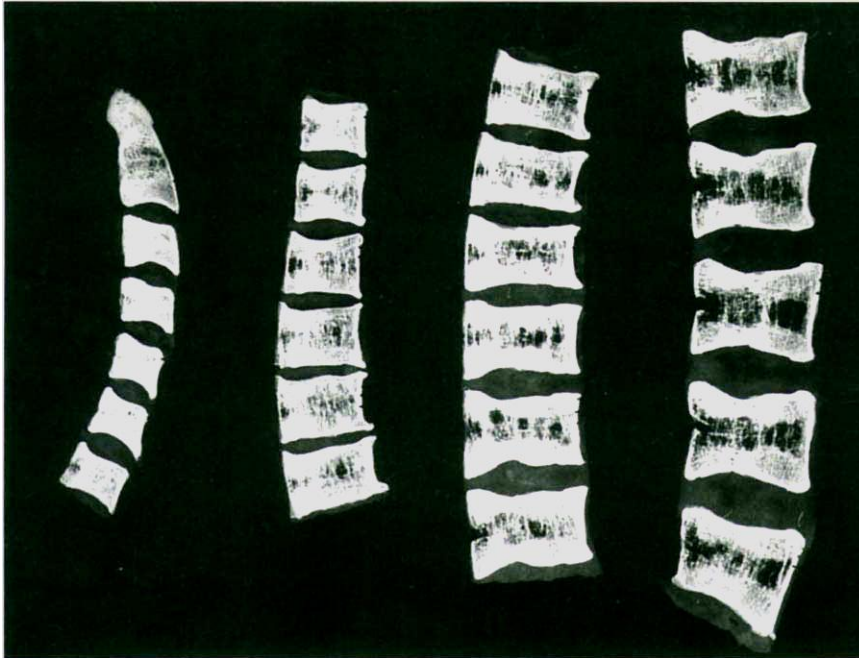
Contact X-ray of a 4 mm thick sagittal spinal segment for the purpose of documentation and determination of SDI. Rubber-jersey-spine, ROD Type IIIc (scale 1:2.4).
